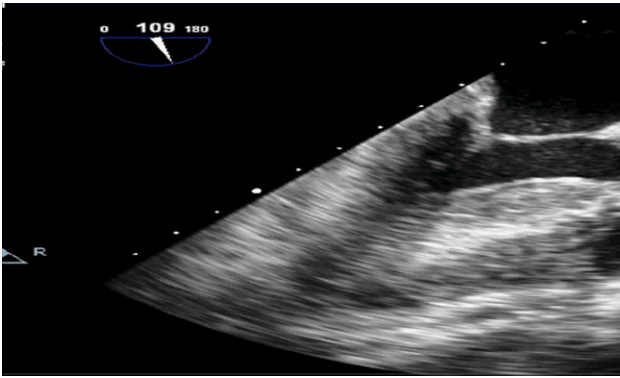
Echocardiogram- Hypertrophic cardiomyopathy
